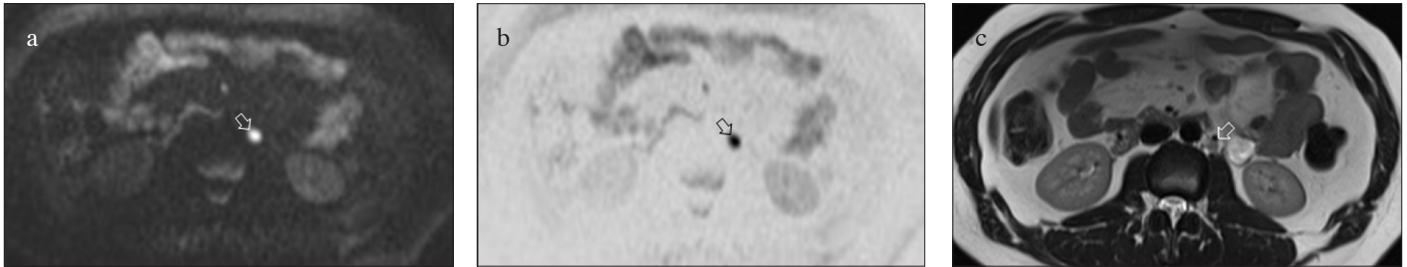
a-c. Abdominal biparametric 3T magnetic resonance imaging after orchiectomy for patients with seminoma shows high sensitivity of diffusion-weighted imaging (DWI) with high b-values (a) and DWI with high b-values inverted (b) in the detection and measurement of enlarged retroperitoneal lymph node (arrow in a and b) that is localized on T2-weighted imaging (arrow in c)
